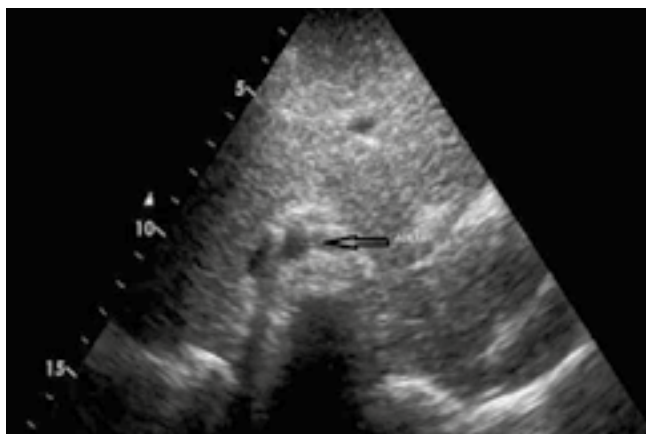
Echocardiography showing right sided aorta
